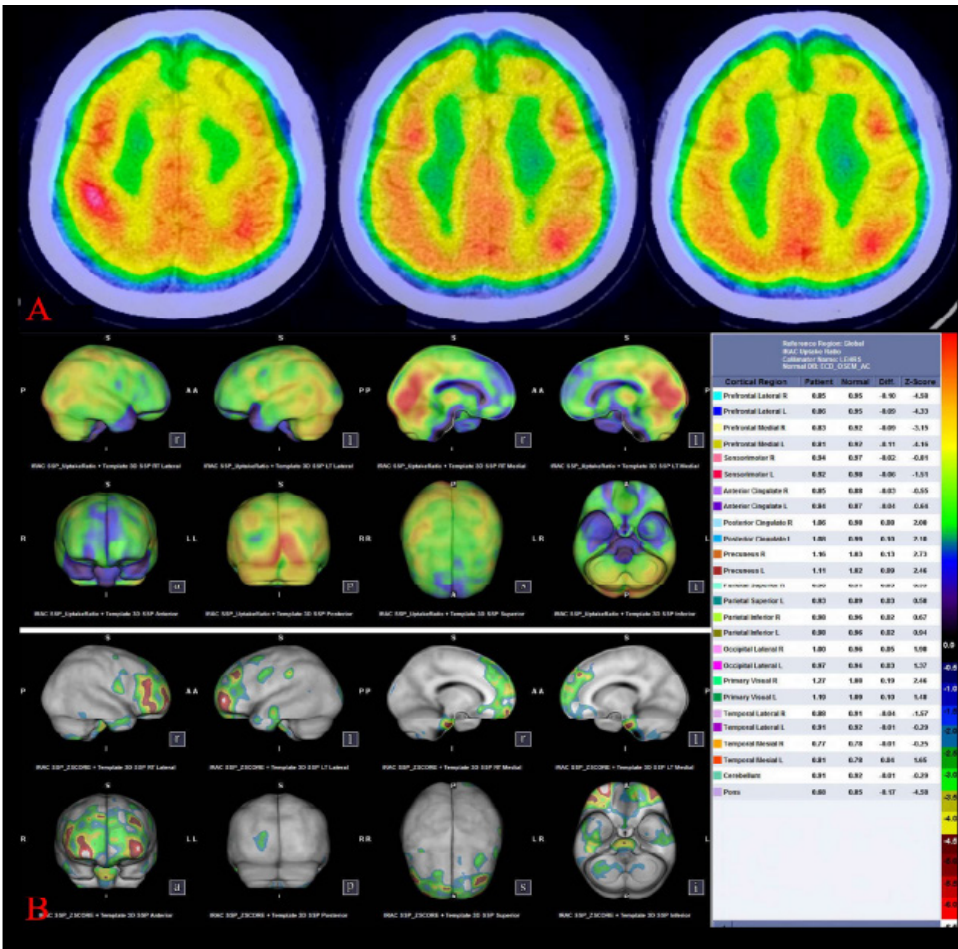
Brain SPECT/CT taken in 2024, after duloxetine (A. transverse; B. 3D)
